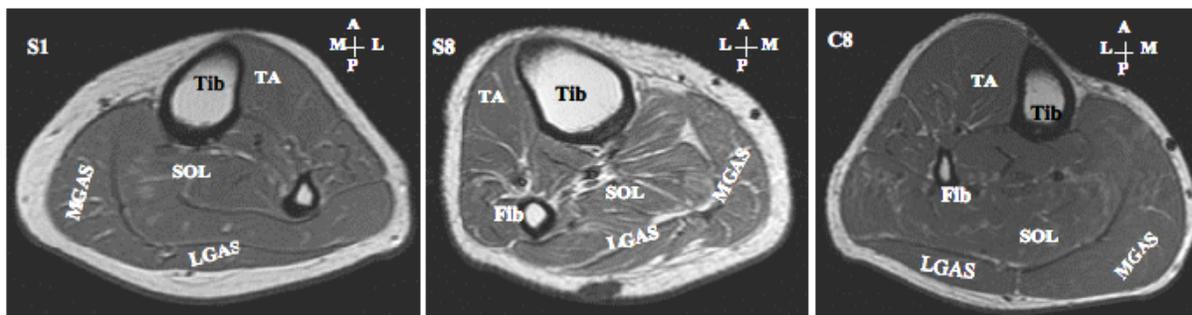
Representative T2 weighted trans-axial proton magnetic resonance images of the lower leg. Ambulatory individual with incomplete SCI (S1) ; non-ambulatory individual with incomplete SCI (S8) ; able-bodied control subject (C8). [A= anterior; P = posterior; M=medial; L=lateral; MG=medial gastrocnemius; LG= lateral gastrocnemius; SOL=soleus, TA=tibialis anterior]
